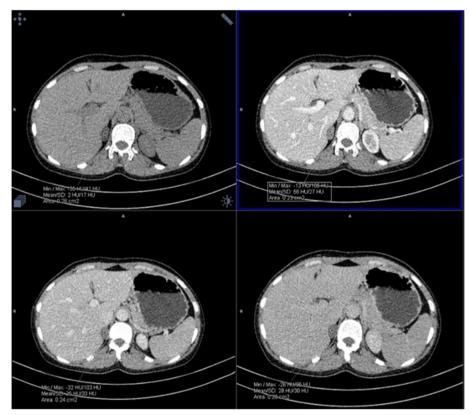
CT density of the lesion in the unenhanced image is < 10HU, considered diagnostic of lipid-rich adrenal adenoma
